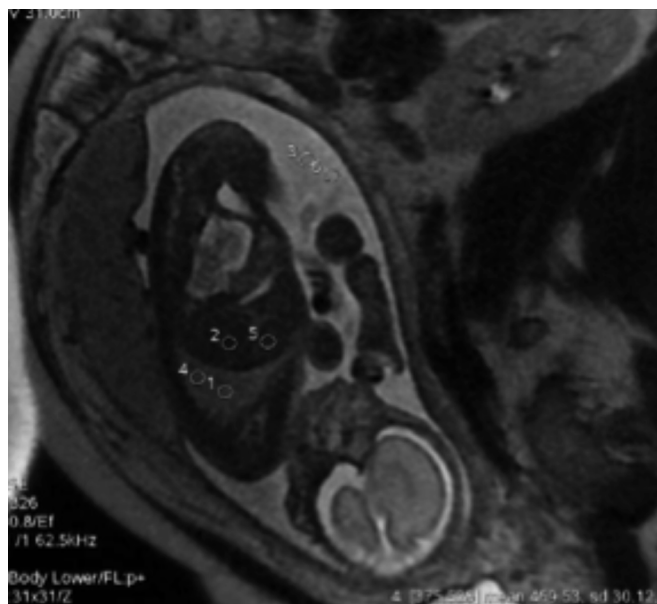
Coronal SSFSE T2-weighted image where 6 ROI were placed.
